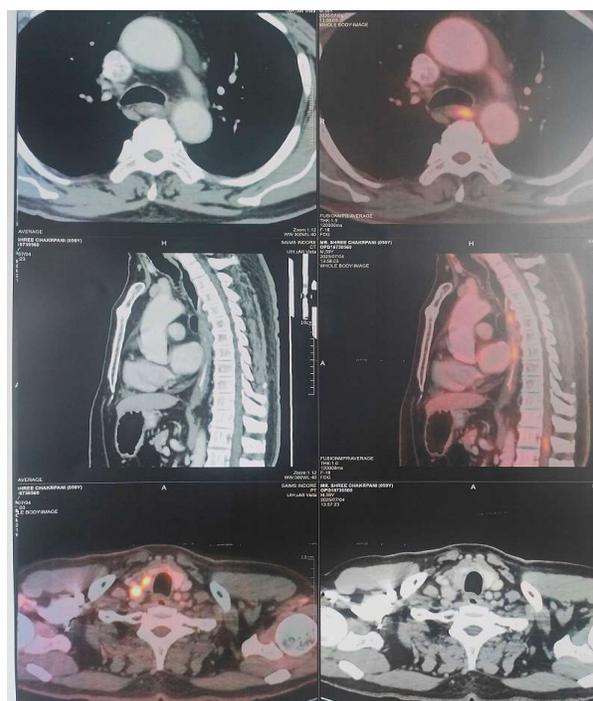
Disease status on PET CT Scan after 6 year of treatment
